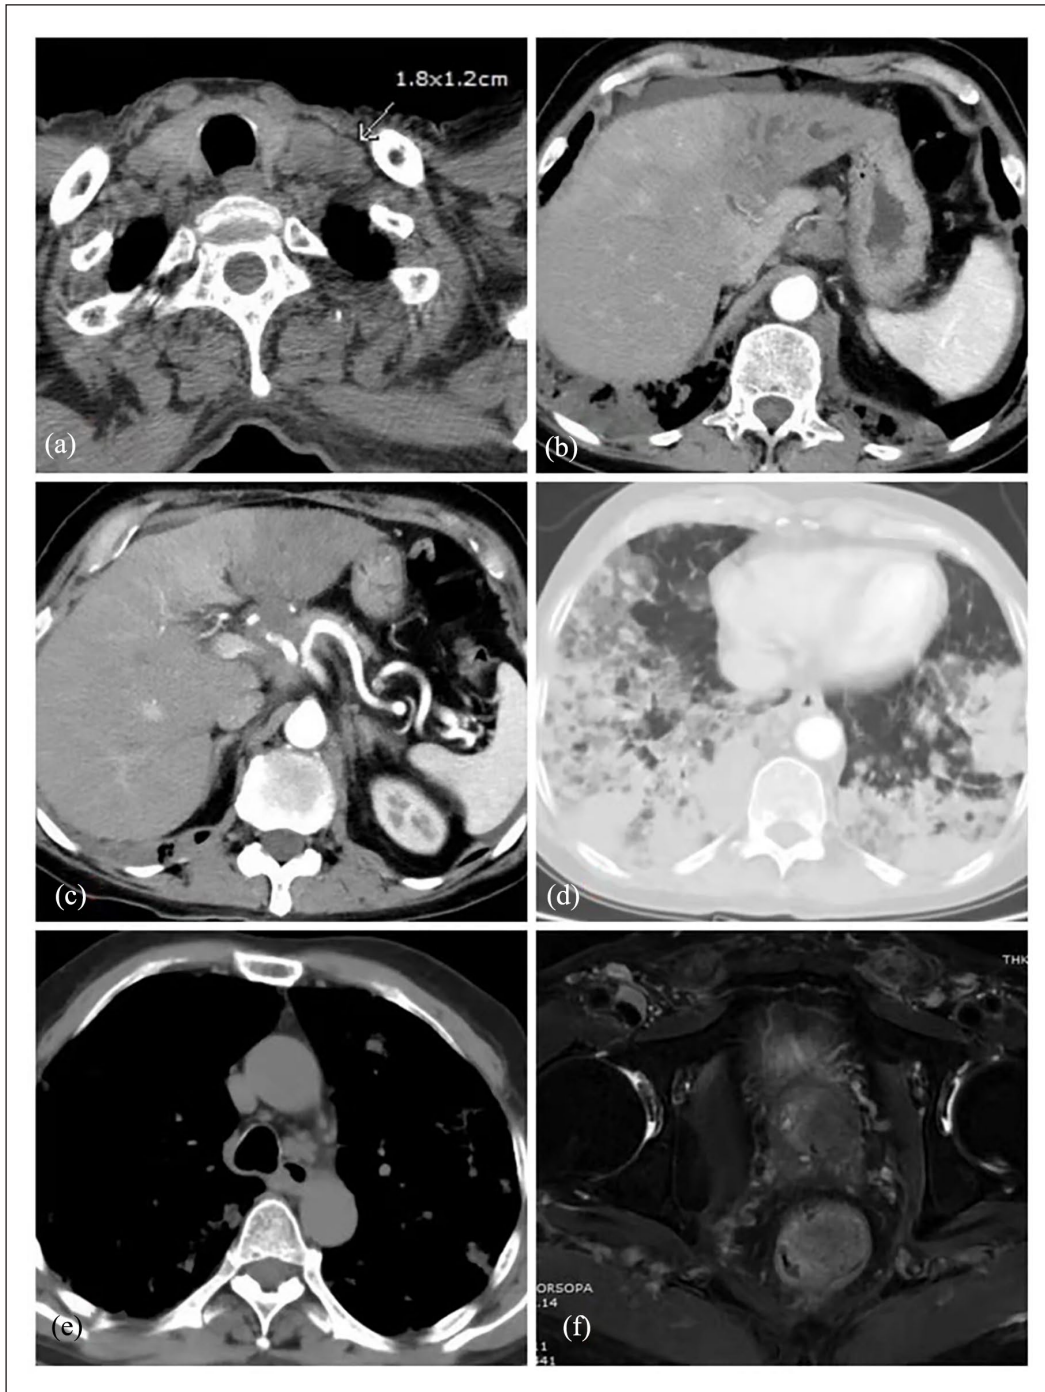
Chest and abdomen computed tomography and pelvic magnetic resonance imaging. (a). Left supraclavicular lymph node enlargement, diameter 1.8×1.2 cm. (b), (c). Left lobe of liver, low-density foci in hilar area, mild enhancement, unclear boundary with pancreatic head, hepatogastric space, abdominal cavity, retroperitoneal lymph node enlargement. (d), (e). Double lung patches, masses, and nodules of primary lung tumors and mediastinal lymph node enlargement. (f). Nodular abnormalities in the left posterior and anterior edges of the prostate, involving both sides of seminal vesicles.
